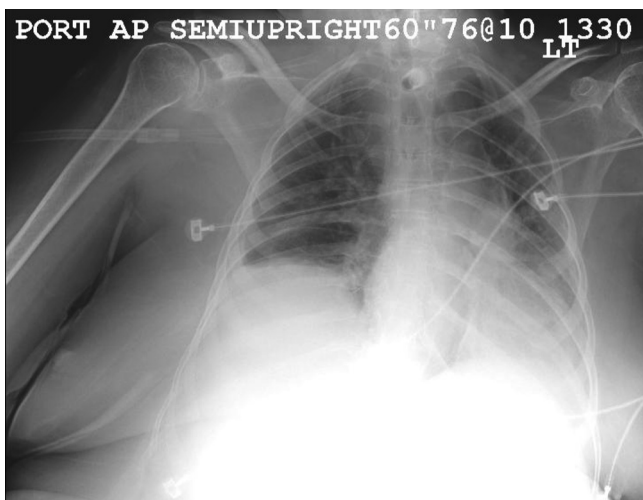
Typical Patient Chest X-ray.
